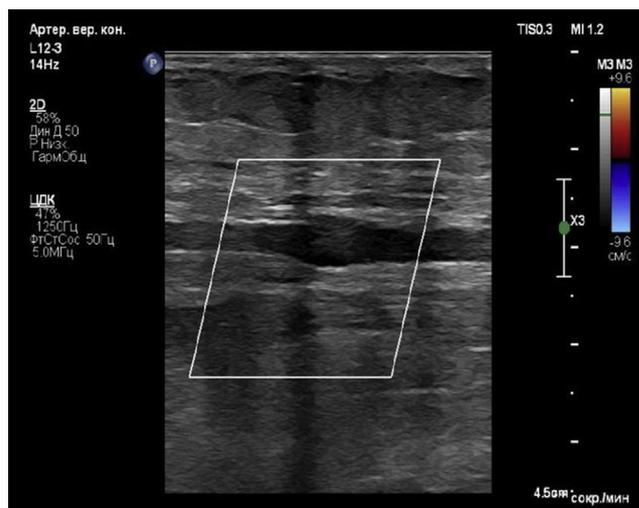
Longitudinal venous ultrasonography with color-flow Doppler, showing thrombosis of the right brachial vein, without color Doppler flow.
